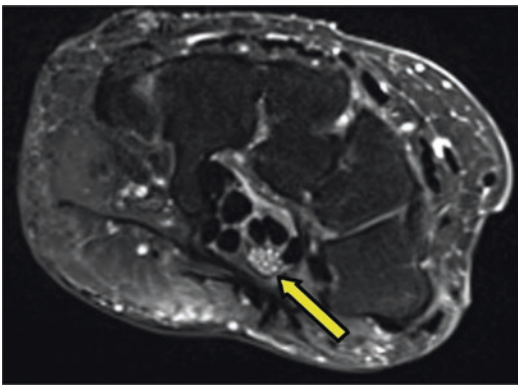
Axial MRI T2 fat saturation—median nerve enlargement with high internal signal (yellow arrow) and bowing of the flexor retinaculum
